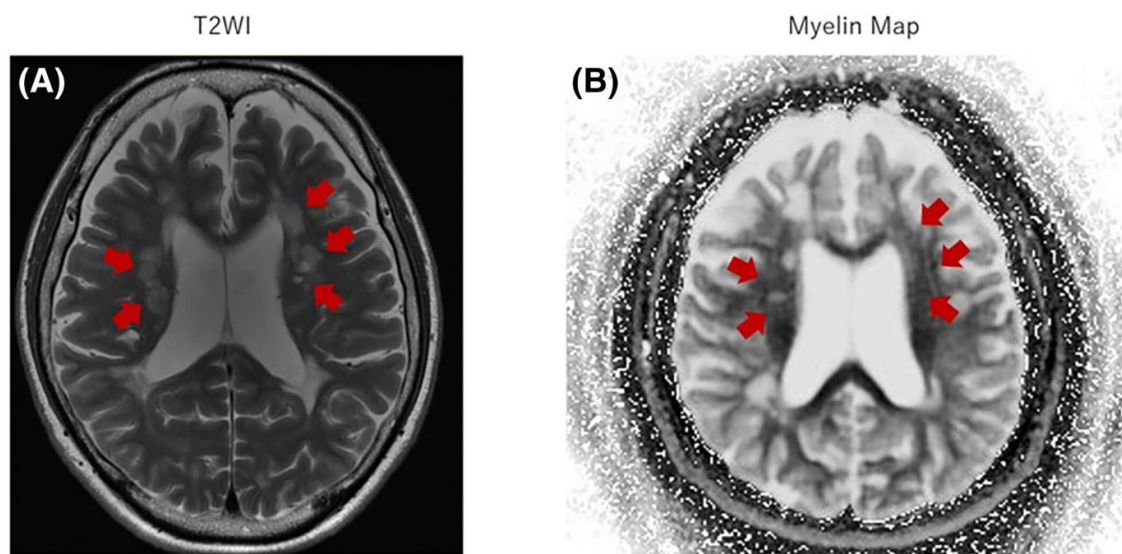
T2-weighted image (T2WI) and q -space Myelin Map (qMM) in a brain of a patient with relapsing–remitting multiple sclerosis (a 60 year old man) are shown. Red arrows indicate multiple sclerosis lesions (i.e. “T2-lesions”) . In qMM image
